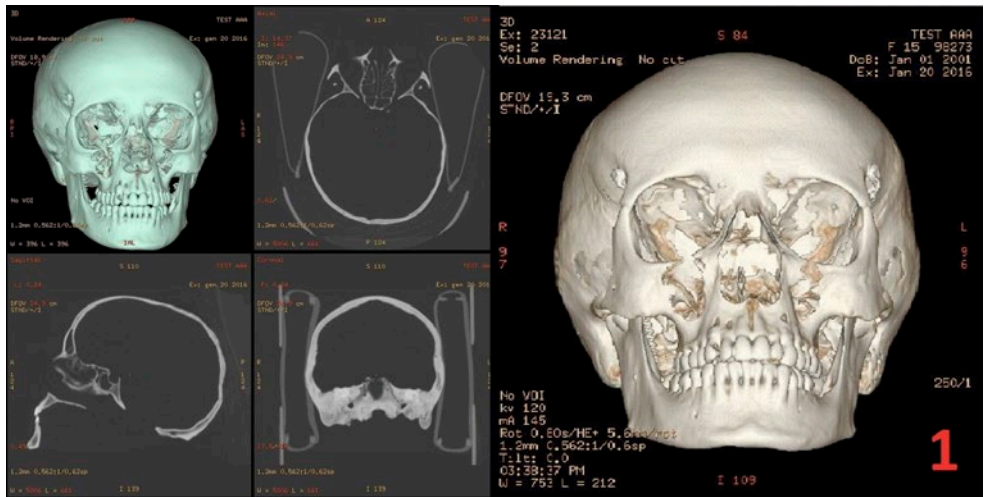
Computerized Tomography (CT) of a human skull.
